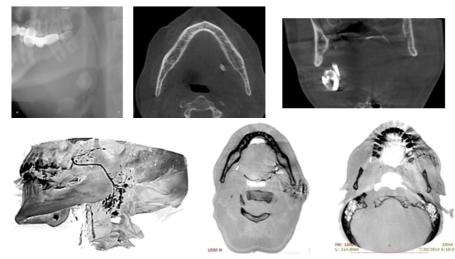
The 3D reconstructions of the sialo - CBCT show stenosis with areas of strictures and dilatation through the glandular ductules
